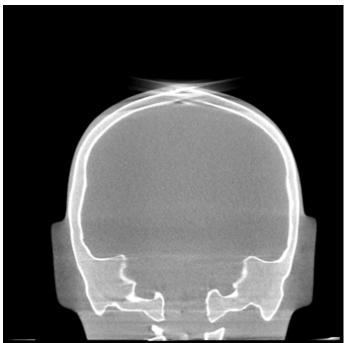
Example of a cone beam artifact at the top of the head
